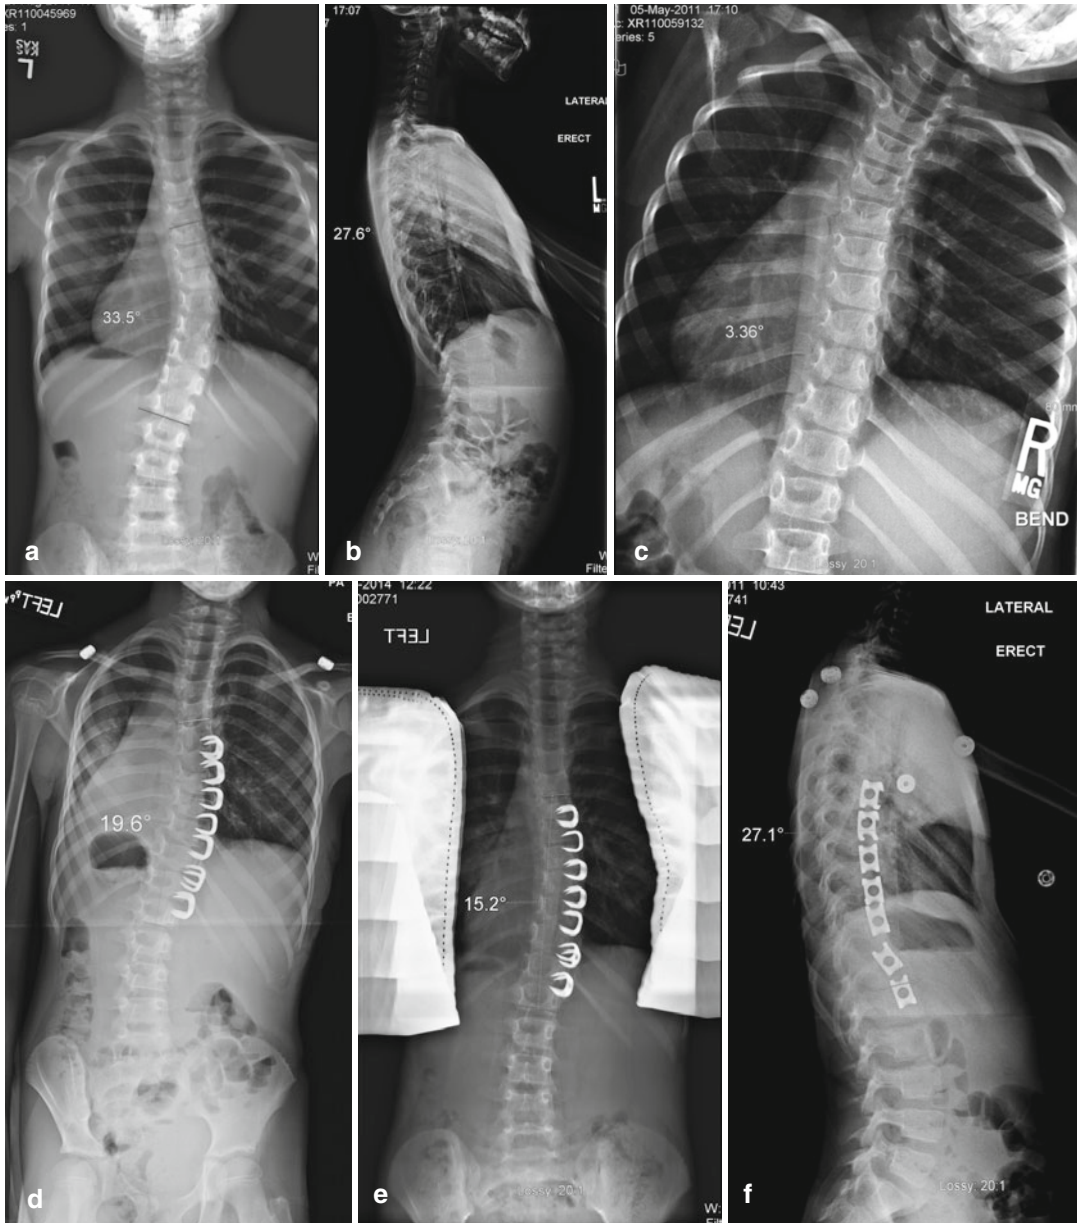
AP (a) and lateral standing radiographs (b) of an 8-year-old female demonstrating a 34° thoracic curve. Preoperative standing radiograph (c) demonstrates the flexibility of the curve. Patient underwent right-sided thoracoscopic VBS from T6 to L1. Her first standing
